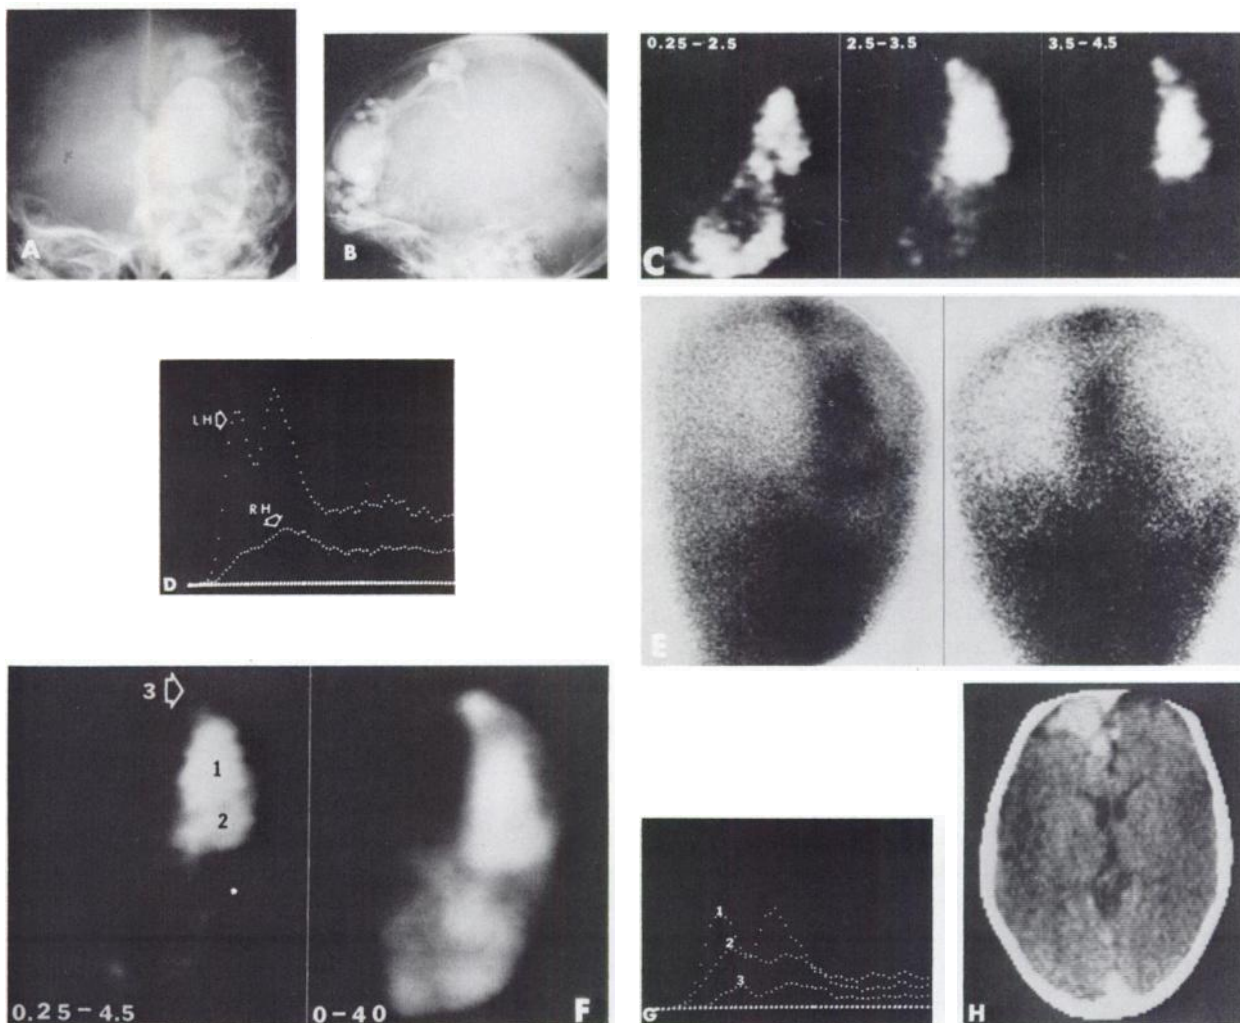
Five-year-old boy (Patient 6) with AVM arising from left anterior cerebral artery (LACA). A-P cerebral angiogram (A) shows AVM fed from LACA. Route of venous drainage was lateral and inferior, with a vein eventually ascending medially to join superior sagittal sinus (lateral radiogram, B). Anterior dynamic scintigraphy (C) with time intervals (sec) indicated, shows left frontal AVM. Curves (D, 0.25 sec/point) show 87% of initial tracer in left hemisphere (LH). LH curve has earlier peak and more rapid recirculation than RH, with curve separation persisting through entire study. (E) Anterior views: sixty-second postinjection (left) and 30-min delayed (right) also show AVM. Route of venous drainage evaluated by placing ROIs (F) over its components (Areas 1, 2) and superior sagittal sinus (#3). Peaks of corresponding curves (G) show sequence of tracer appearance in these regions, confirming that AVM initially drains inferiorly before its content reaches superior sagittal sinus. (H) CT scan after contrast injection shows left frontal AVM, which was not identified on precontrast scans.
